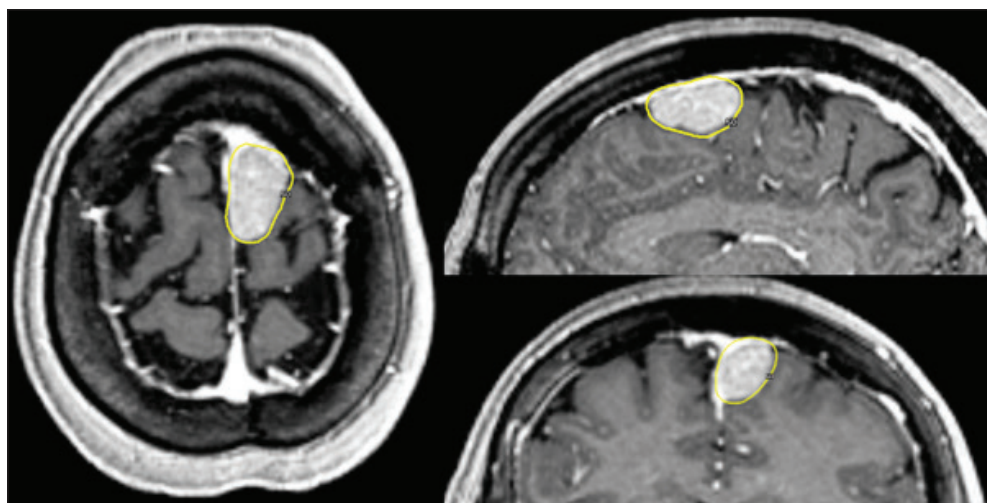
Axial, sagittal, and coronal post-contrast T1W MRI images show an asymptomatic parasagittal meningioma (tumor volume: 4.2 ml) in a 68-year-old female patient. The prescribed Gamma Knife treatment plan was a dose of 12 Gy to the 50% isodose line (yellow contours).
